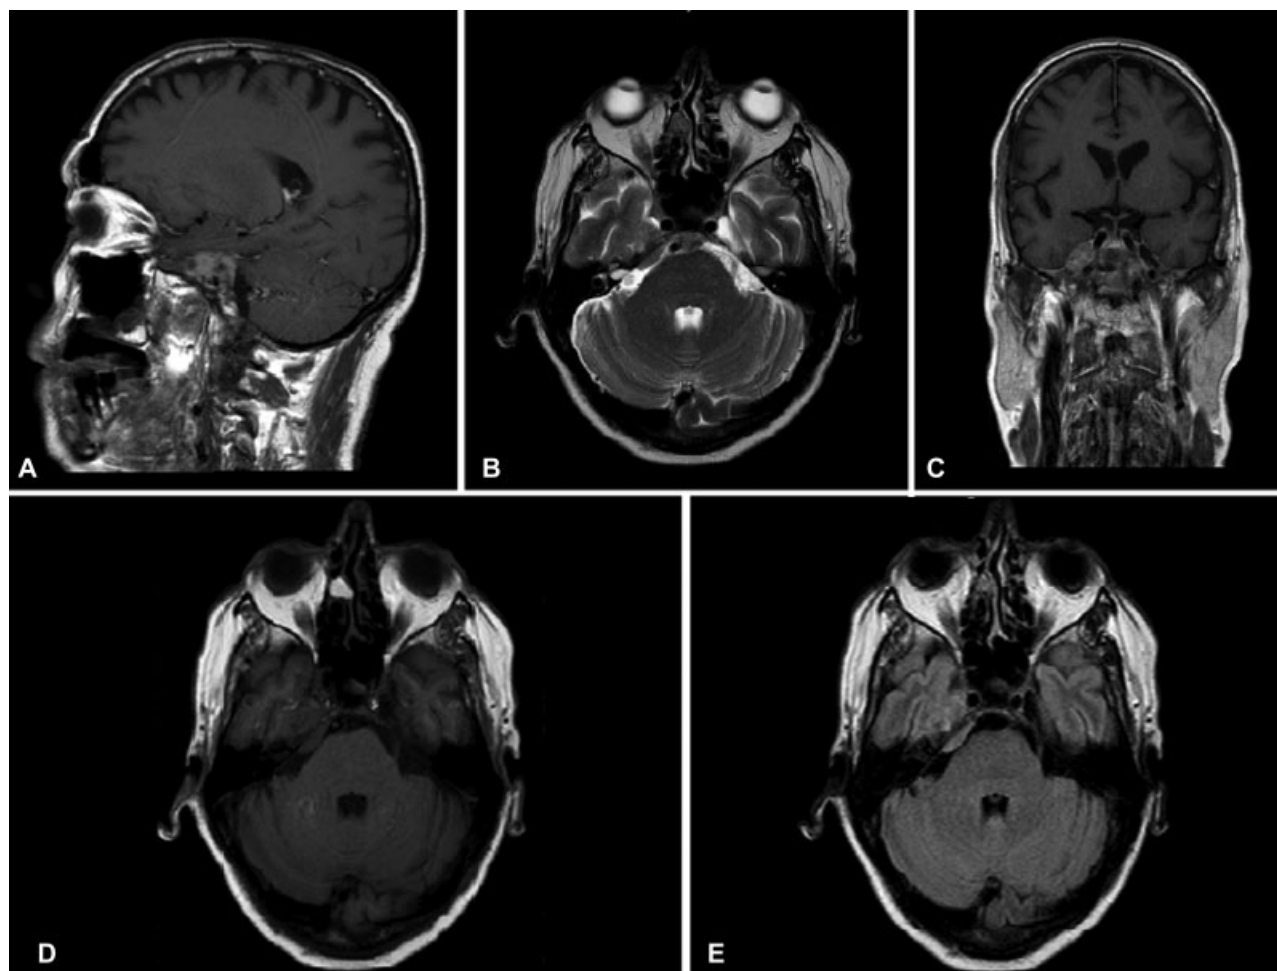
Preoperative magnetic resonance imaging (MRI) evaluation. In this, we observed an expansive lesion at the root of the trigeminal nerve, in the trigeminal cave. (A) T1 weighted imaging (T1WI) postgadolinium MRI, sagittal view; (B) T2 weighted imaging postgadolinium, axial view; (C) T1WI postgadolinium MRI, coronal view; (D) T1WI MRI, axial view; (E) Axial fluid-attenuated inversion recovery (FLAIR).
